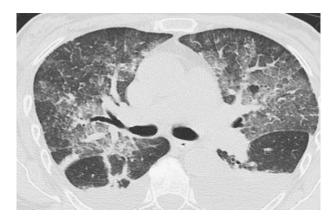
CT image of chest showing extensive bilateral crazy paving pattern more in perihilar regions.²⁰
